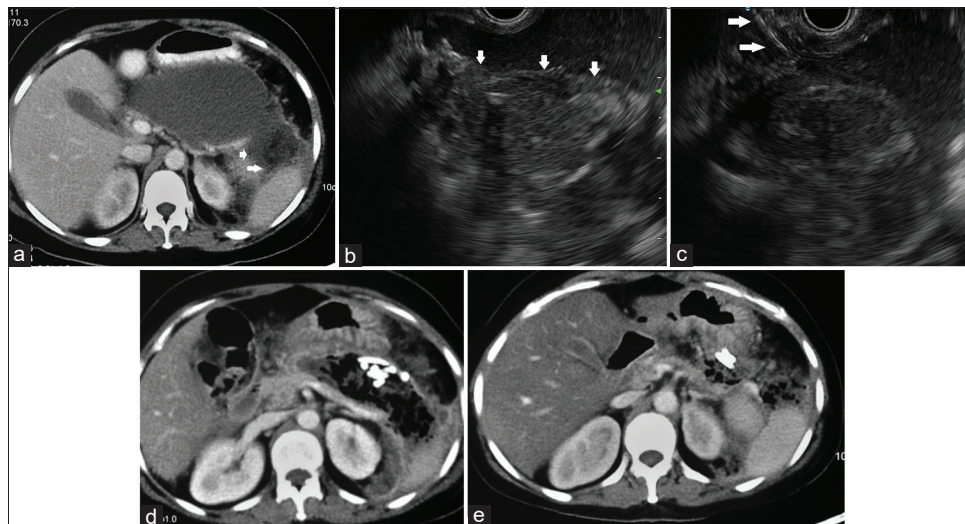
(a) Computed tomography: Large necrotic collection with partially formed encapsulating wall. The area where wall seems to be incomplete has been highlighted with arrows. (b) EUS: Necrotic collection with mixed solid-liquid necrotic content. The solid content has been highlighted with arrows. (c) EUS guided drainage of necrotic collection. Transmurular tract being dilated with biliary balloon (arrow). (d) Computed tomography: Residual necrotic collection with multiple plastic stents after three session of ETD and DEN. (e) Computed tomography after five session of DEN. Small residual necrotic collection with complete clinical recovery. Plastic stents are noted. ETD: Endoscopic transluminal drainage; DEN: Direct endoscopic necrosectomy
